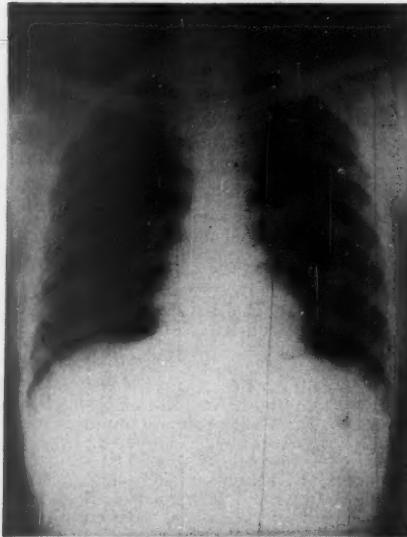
Preoperative chest x-ray showing broadening of the upper mediastinal shadow and displacement of the trachea to the right.
